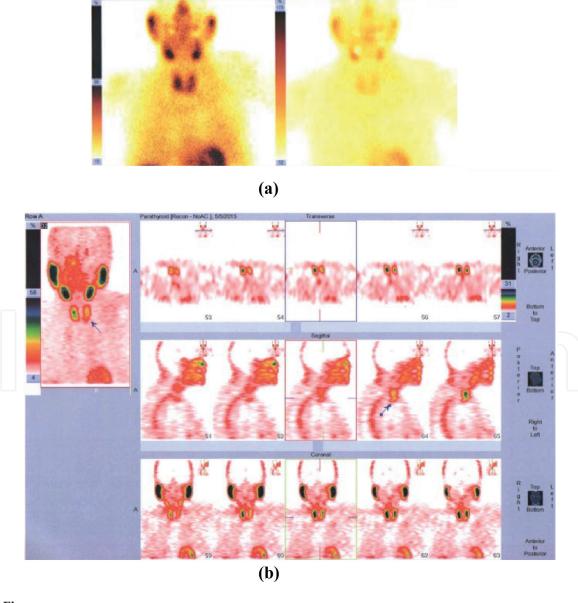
(a) Single-isotope dual-phase scintigraphy with ^{99m}Tc-sestamibi. Early planar images show diffuse uptake in the thyroid gland. Late planar images show no sign of a focus of residual activity in the neck area or mediastinum. (b) (The same patient) ^{99m}Tc-sestamibi SPECT images show an area of a residual activity, located dorsally and caudally of the left thyroid lobe (arrows) suspicious for a parathyroid adenoma.
